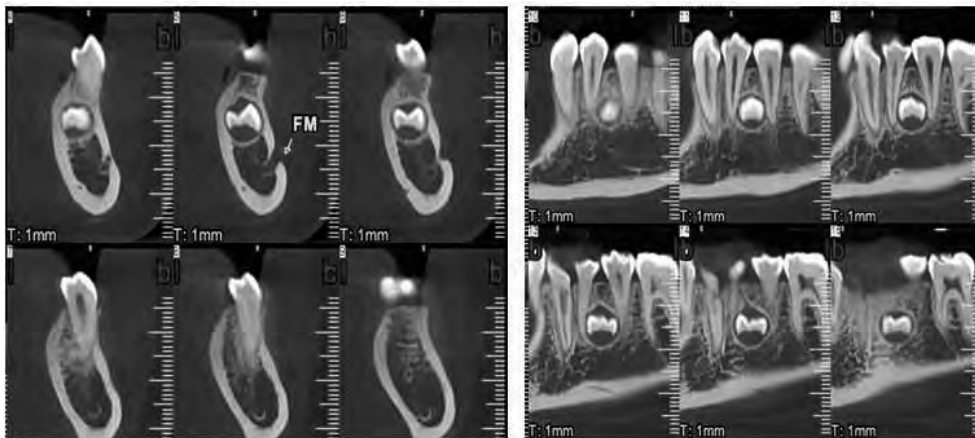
The computed tomography cross-sectional images show that the developing crown of the supernumerary premolar had a slight lingual displacement, and that it was moving the roots of the adjacent bicuspids without any remarkable evidence of root resorption. The crown was at a safe distance from the alveolar nerve emergence.
